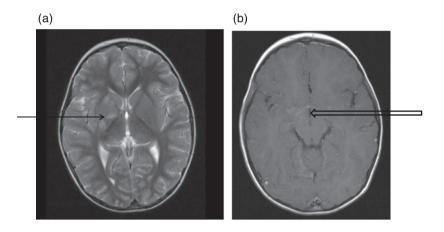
Stroke mimic/infection/tuberculous meningitis. Four-year-old male presented with acute left hemiplegia and was initially diagnosed to have stroke. He had history of fever and neck stiffness. Magnetic resonance imaging showed high-signal T2 changes in the right basal ganglia region (a) and basal meningeal enhancement after contrast (b). Cerebrospinal fluid showed evidence of inflammation, and the γ -interferon test for tuberculosis was positive. This case highlights the importance of identifying and treating infection in children with suspected stroke.
